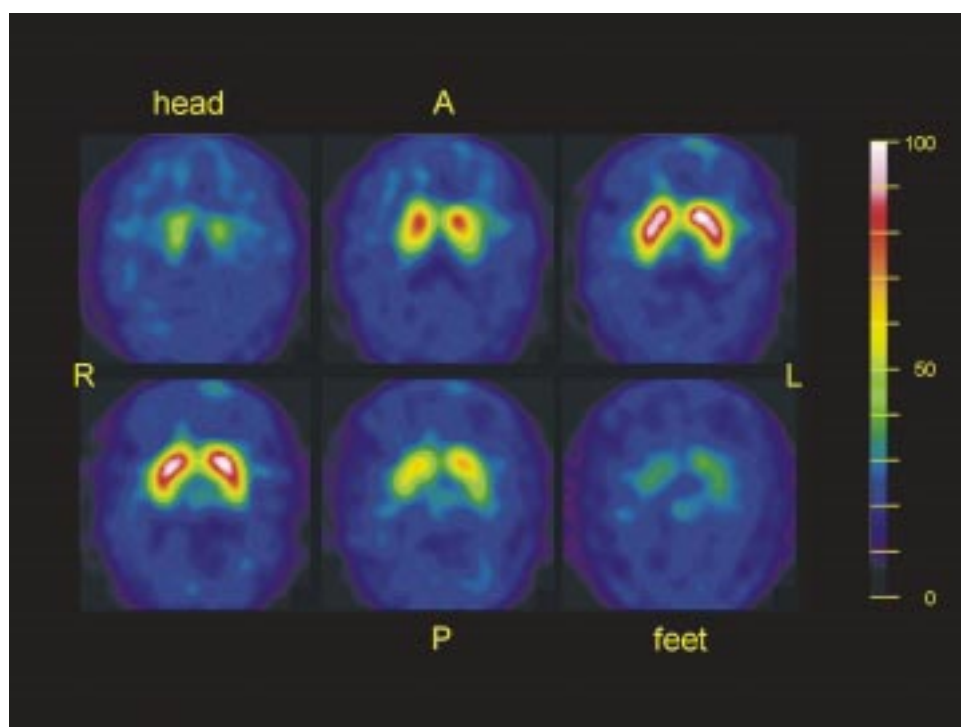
19-year-old patient with bilateral tremor of the hands. SPECT images were obtained 3 hours after the application of 200 MBq ¹²³I-FP-CIT, a cocaine derivative. This examination was performed in order to differentiate Parkinsonian syndrome from essential tremor. Note the physiological tracer uptake in both striata pointing towards an essential tremor.
